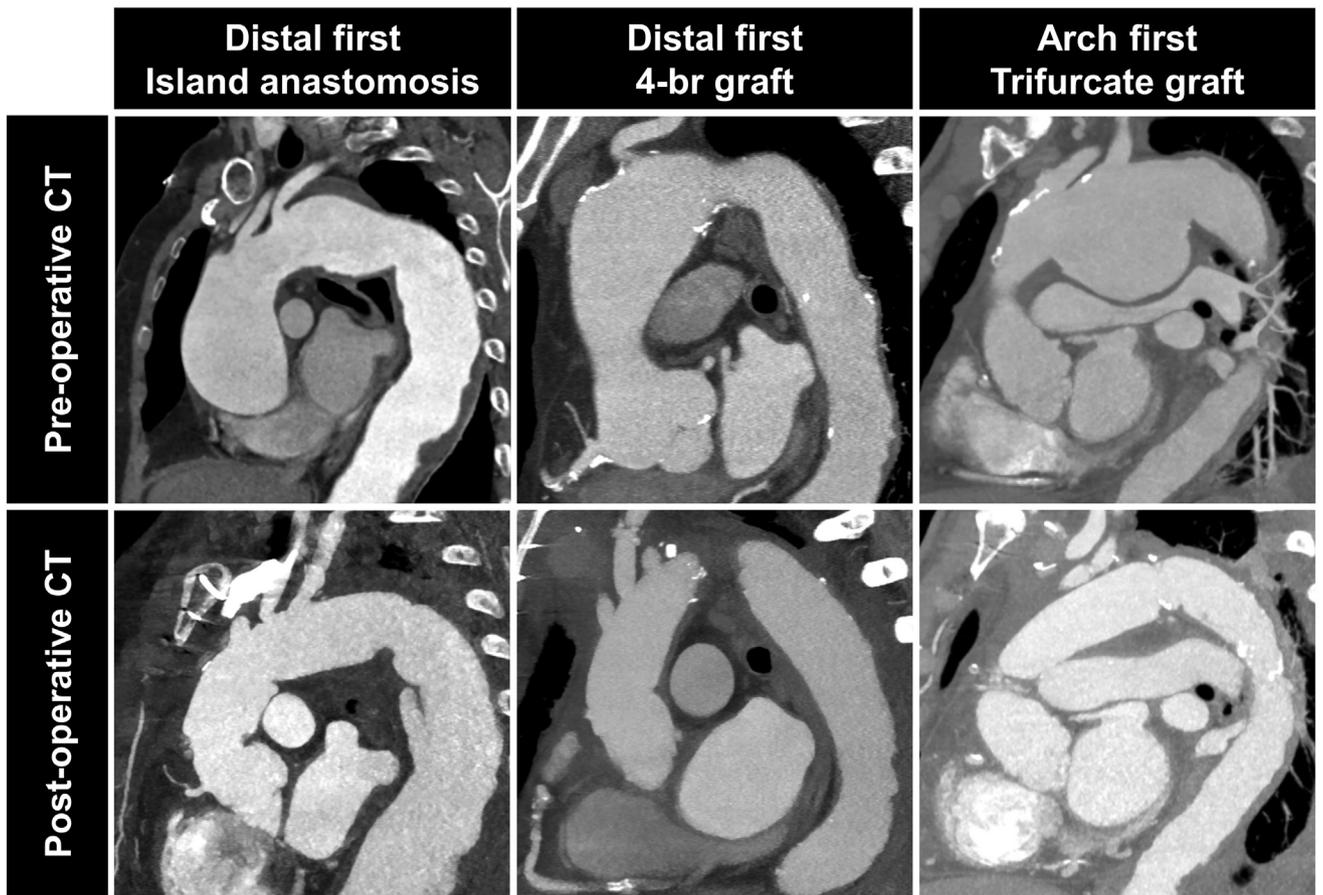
Representative preoperative and postoperative computed tomography (CT) scan images for each surgical strategy employed in mini-access total arch replacement. *br*, Branch.
